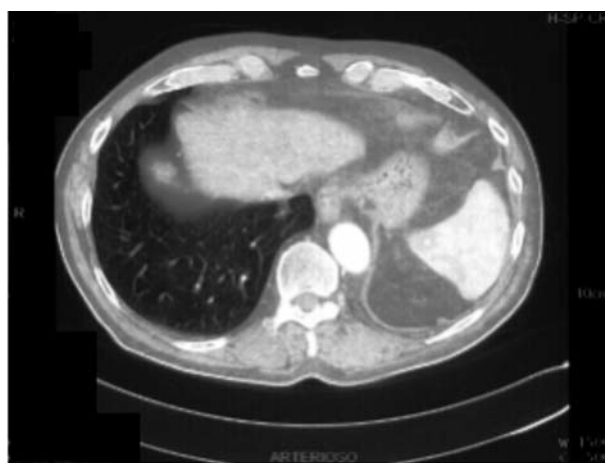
Thoracic CT scan (January 2010). Lung metastatic node is 15×11 mm in maximum diameter.
